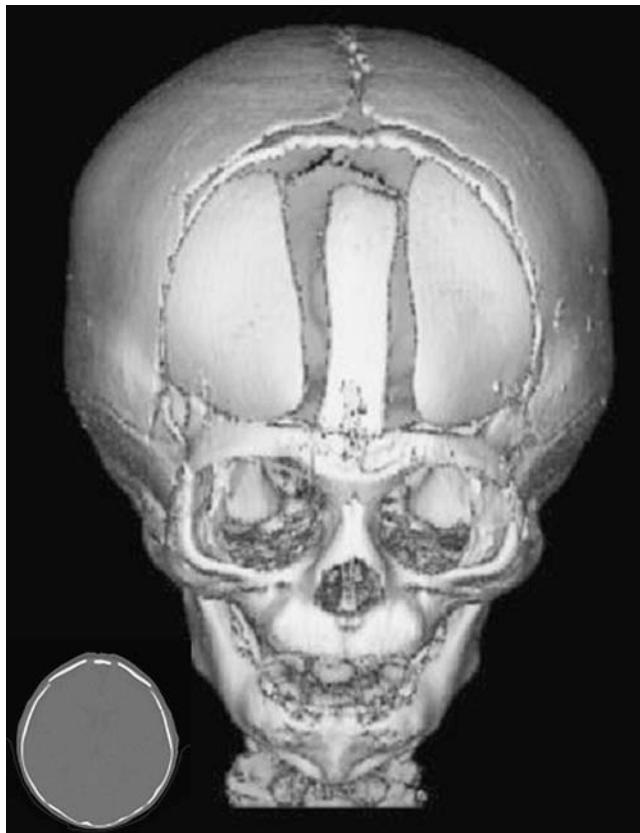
Postoperative CT data. 3D CT showing the actual osteotomy segments
